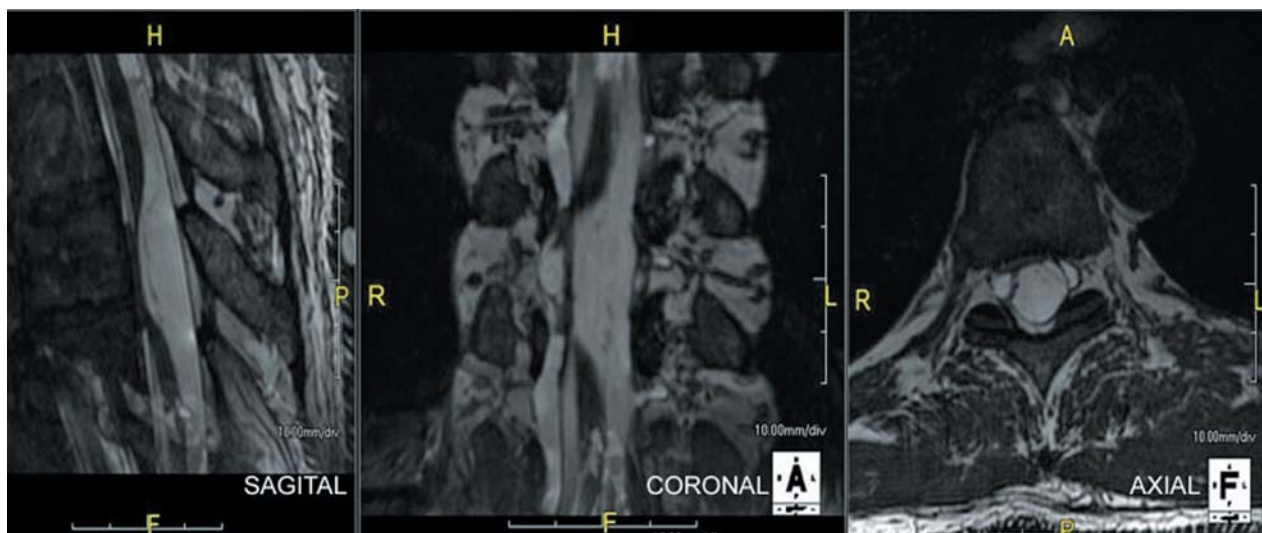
Magnetic resonance imaging examination in sagittal, coronal, and axial views of the ventral herniation of the thoracic medulla through the dural defect. At this level, the spinal cord appears narrowed and deformed, with accumulation of cerebrospinal fluid in the subarachnoid space.
